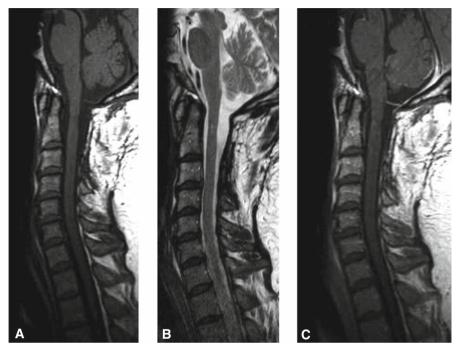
C2 ependymoma. Post operative MRI 6 years after complete removal. A T1Wi, B T2Wi: only a small residual cavity is seen. C Gadolinium T1Wi: no more contrast enhancement
